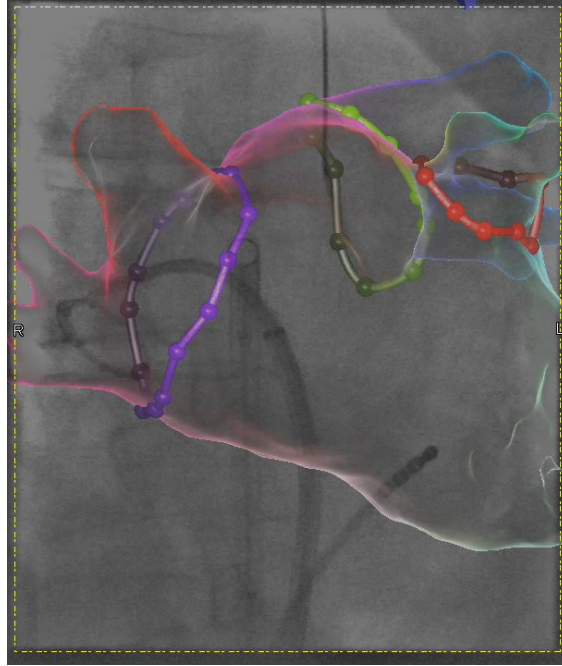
Due to the low soft tissue contrast of X-ray images, the heart anatomy is not visible in fluoroscopy images. To overcome this limitation, a 3-D model (coloured shape) of the patient’s heart can be overlaid to the image. Moreover, annotations relevant to the procedure (lines with dots) can be displayed as well.
